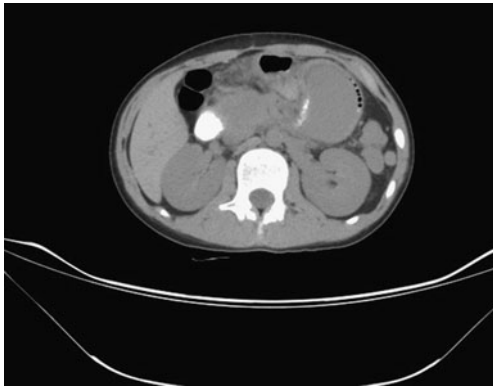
Oral contrast CT scan revealed a large mass occupying the majority of the jejunal lumen with luminal narrowing
